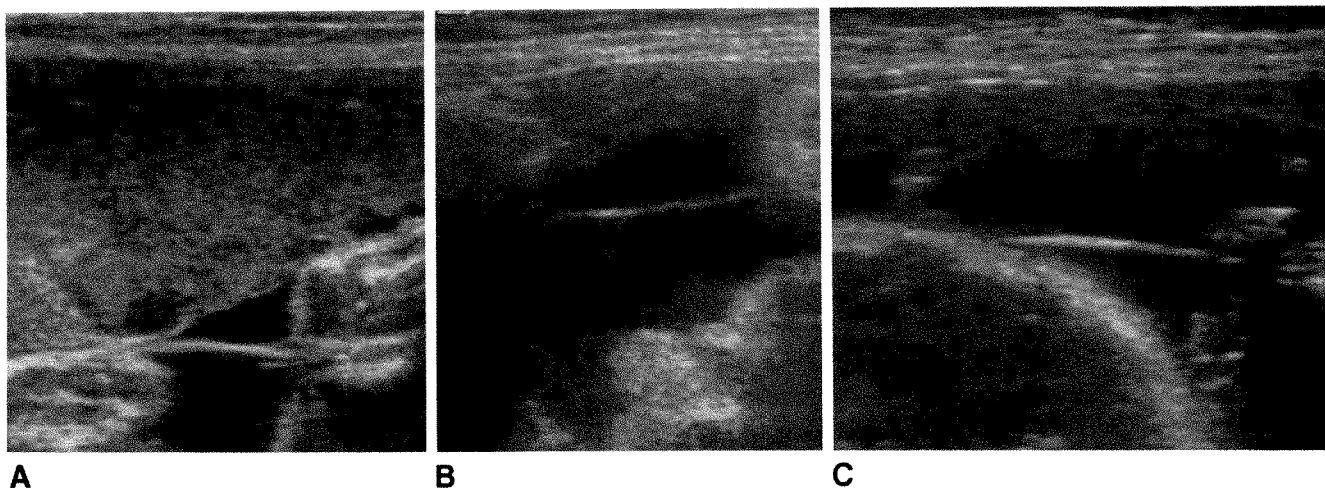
A–C, False thick appearance of membrane on sonograms in three different cases of proved monochorionic diamniotic gestations. Membrane is artifactually thickened by specular reflection as beam strikes membrane perpendicularly.
